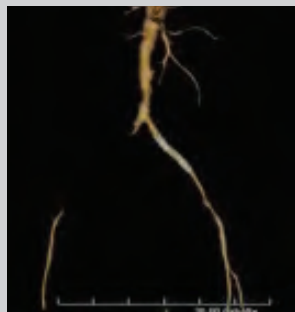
CT angiogram demonstrating the right iliac occlusion
